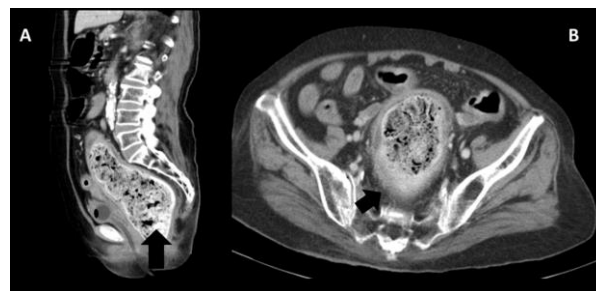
Computed tomography (CT) of abdomen revealed fecaloma in the rectum with inflammatory rectal wall and peri-rectal fat stranding.
